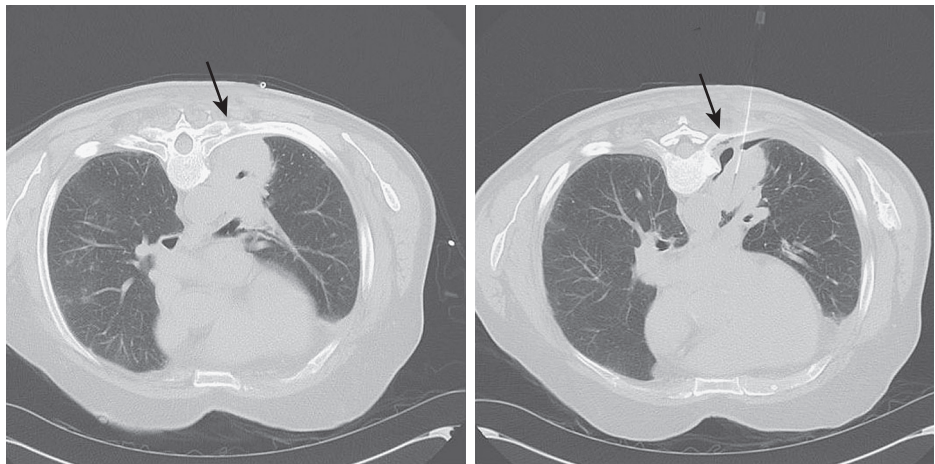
■ A CT of the chest reveals a lung mass abutting the posterior rib (arrow in left image). A review of the images obtained during transthoracic needle biopsy showed the mass moving away from the chest wall with a minimal focal area of pneumothorax (arrow in right image). Other images revealed complete separation from the chest wall. Note: The patient is prone in these scans for obtaining the biopsy.
